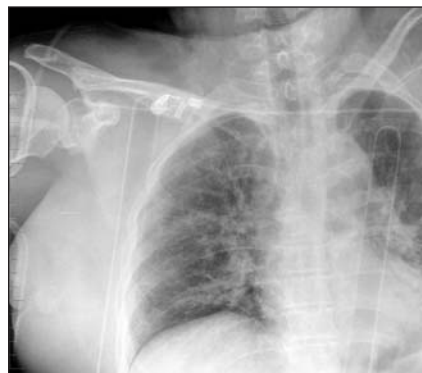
Initial chest radiograph: probable bilateral pulmonary contusions were diagnosed. No mediastinal injury was seen; this was confirmed with infused CT scan.
